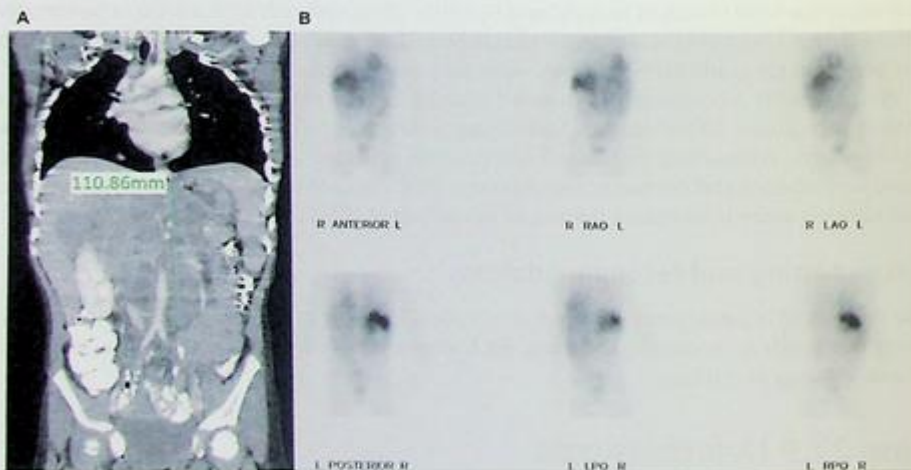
Chest CT and MIBG results from the patient. (A) Chest CT demonstrated a large central and upper retroperitoneal mass, measuring $12.9 \times 11.1 \times 8.2$ cm, arising in the right adrenal gland, and extending into the hilum of the right kidney. (B) MIBG scan showed MIBG accumulation at the site of the patient's right-sided intra-abdominal mass.
